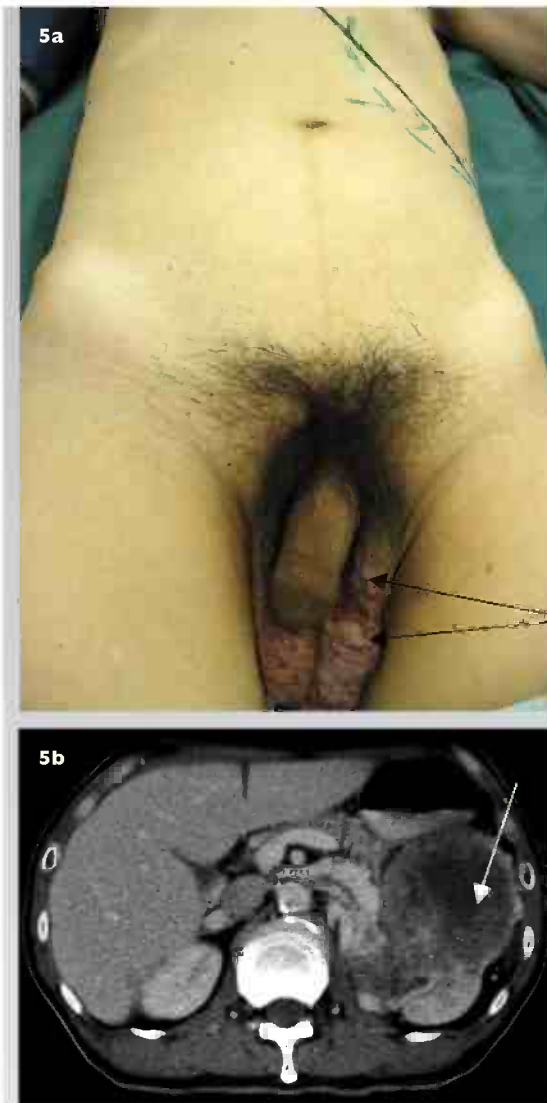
(a) Clinical photograph of a middle-age man presenting with a non-reducing left varicocele (arrows) and a ballotable left renal mass. (b) Axial CT image shows a large left RCC (arrow).
